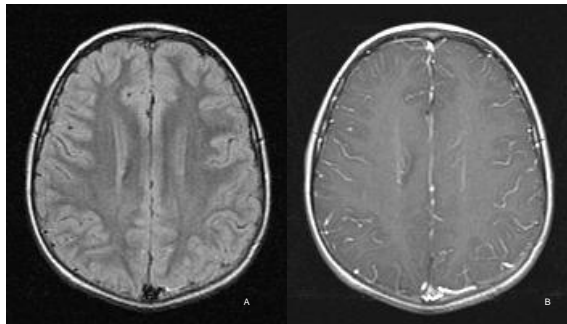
Axial FLAIR (A) and T1 with Gadolinium (B) of a 6-year-old boy, who presented with secondary generalized epilepsy and normal EEG. There was diffuse cortical edema with markedly increased leptomeningeal and intravascular enhancement at the left superior parietal gyrus, most likely due to viral encephalitis
